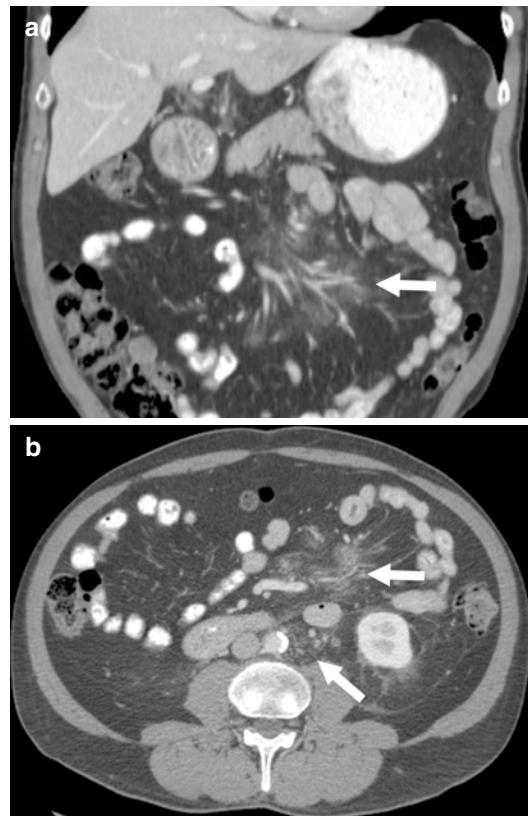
Mesenteric and retroperitoneal stranding due to ipilimumab. A 67-year-old male with metastatic melanoma received a total of 11 cycles of ipilimumab and temozolamide. (a) Coronal CT after 4 months of chemotherapy shows increased hazy density of the mesenteric fat (arrow). (b) Axial CT shows increased opacity of the retroperitoneal and mesenteric fat (arrows). The patient had skin rash, fatigue, and dyspnea due to therapy, and he was taken off the study 6 months after this scan
